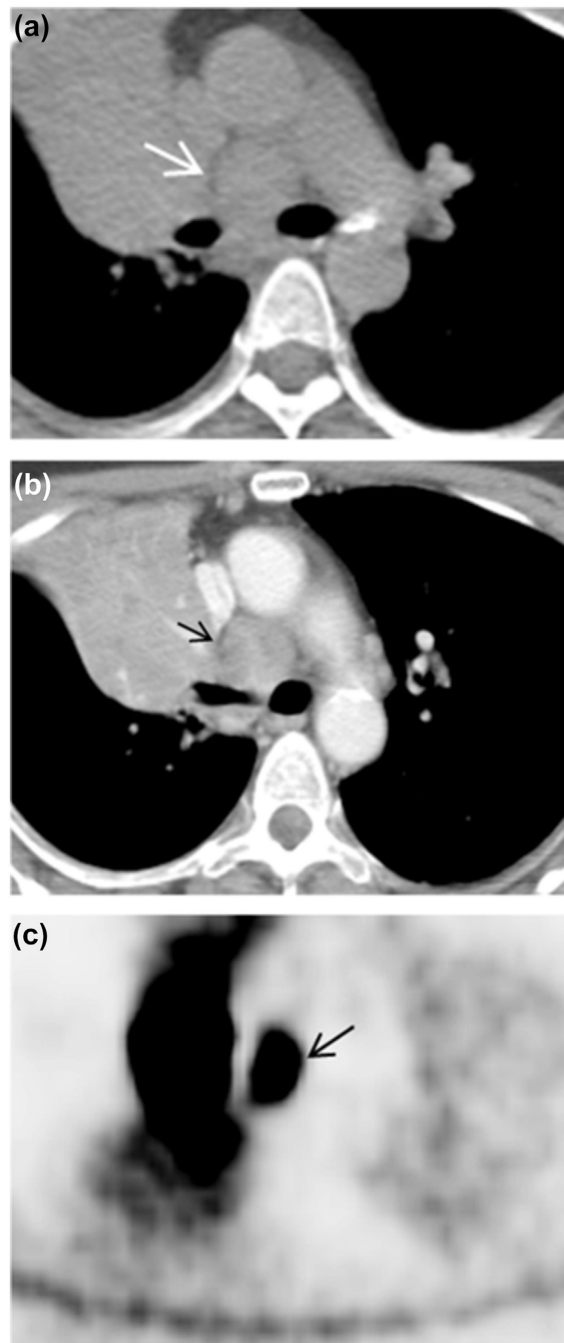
Axial CT image with (b) and without IV contrast (a) revealed lymph node enlargement on 4 (arrow). Long-axis diameter is 2.49 cm, and short-axis diameter is 2.36 cm. The axial S/L ratio is 0.95. Non-enhancement contrast CT value and enhancement contrast CT value were 42.52 and 90.21HU, respectively. The lymph node had un-sharpness border. Axial PET image (c) revealed the lymph node has high FDG uptake (arrow). The pathology result is B lymphoma.
